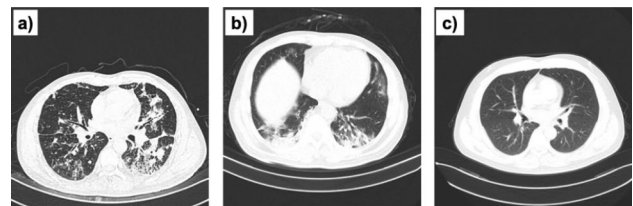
Sample chest X-rays taken from the COVID-19 Radiography dataset. a Normal case, b COVID-19 case showing bilateral ground-glass opacities with prominent peripheral, perihilar and basal distribution within a multilobar involvement, and c viral pneumonia case with visible left basilar opacityFig. 3 CT images taken from COVID-19 CT Scan dataset. Typical examples showing a common pneumonia (CP), b COVID-19 (NCP), and c normal CT scan images
